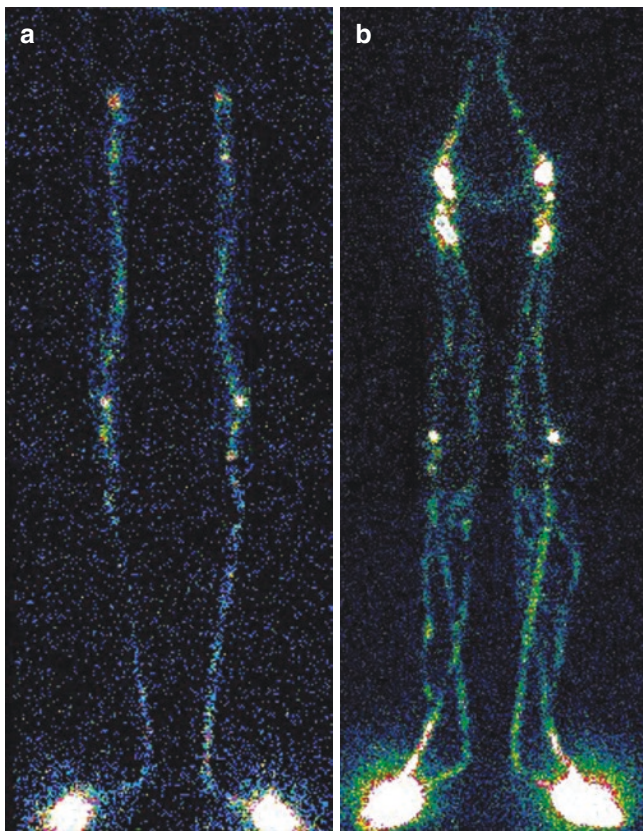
Typical example of a normal pattern of two-compartment lymphoscintigraphy in lower limbs. (a) Step one of lymphoscintigraphy, obtained after deep injection as described in the text: symmetric migration of the radiocolloid along the vessels of the deep lymphatic circulation, with visualization of both the popliteal and the inguinal lymph nodes. (b) Step two of lymphoscintigraphy, obtained after subsequent radiocolloid injection in the subdermal space, as described in the text; in addition to the deep lymphatic vessels (still visualized by prior deep radiocolloid injection), the superficial lymphatic circulation is now visualized. The image represents therefore the sum of the two lymphatic systems, deep and superficial. From the superficial injection site a single lymphatic vessel originates on both sides, immediately dividing into two collaterals, one pointing symmetrically along the medial portion of the legs and thighs until the groin and the other pointing laterally; both vessels merge at the groins into the inguinal lymph nodes and continue in the main pelvic and abdominal lymphatic system
